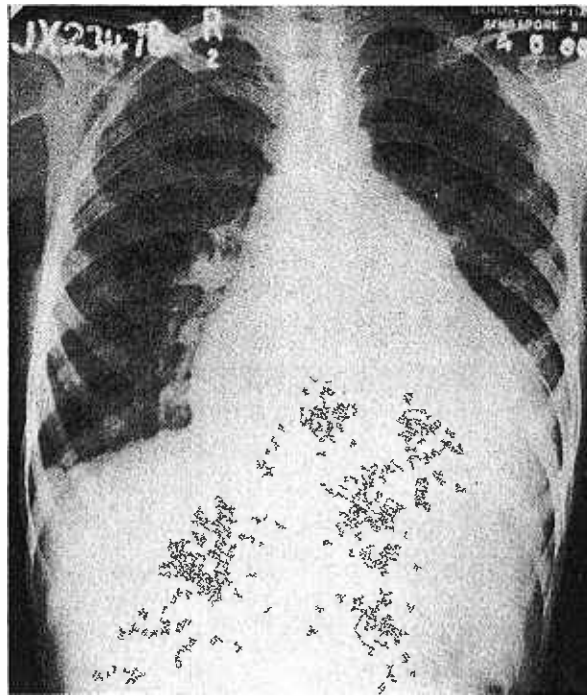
Roentgenogram of thorax showing marked cardiac enlargement.
